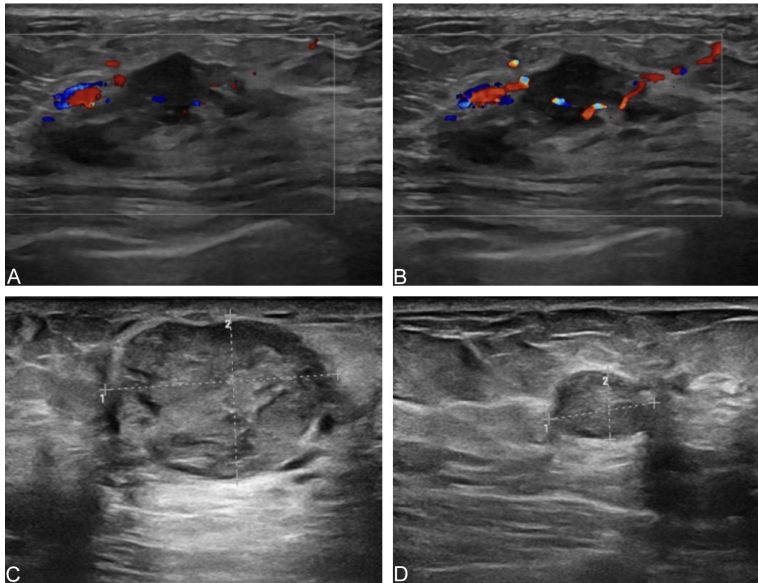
Typical case ultrasound image. A, B: A 58-year-old female with a right breast biopsy showing three fine thread-like tissues, grayish-white and grayish-yellow in color, measuring 0.8-1 cm in length and 0.1 cm in diameter. The biopsy was confirmed as invasive breast cancer. The contrast-enhanced ultrasound of the patient revealed a peak time of 18.48 seconds, enhancement amplitude of 5.98 dB, ascending slope of 15.22, area under the curve of 469.45, and a gradient of 1.09. Both Her-2 and CD147 expressions in the cancer tissue were positive. C, D: A 71-year-old female with a left breast mass measuring 24 × 21 × 5 cm. No abnormalities were observed on the skin surface or nipple. The clinical incision site revealed a mass of 3.5 × 3.5 × 2.5 cm, containing a significant amount of mucus and soft in texture. The mass was adjacent to the skin and nipple, approximately 3 cm from the resection margin. The remaining breast tissue was grayish-white and grayish-yellow with soft texture. The mass was confirmed as solid papillary carcinoma with invasion. The contrast-enhanced ultrasound of the patient revealed a peak time of 19.34 seconds, enhancement amplitude of 7.38 dB, ascending slope of 12.94, area under the curve of 419.38, and a gradient of 1.30. Both Her-2 and CD147 expressions in the cancer tissue were positive.
